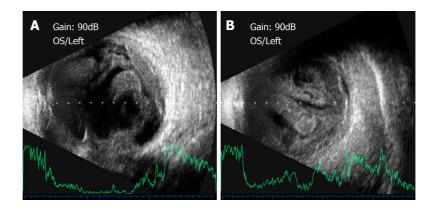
B-ultrasonography. A: Vitreous opacities with retinal detachment; B: Deteriorating vitreous opacities and retinal detachment.
